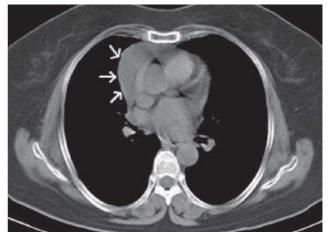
Follow-up contrast enhanced computed tomography of chest showing para-mediastinal effusion (white arrows) in the same area.
